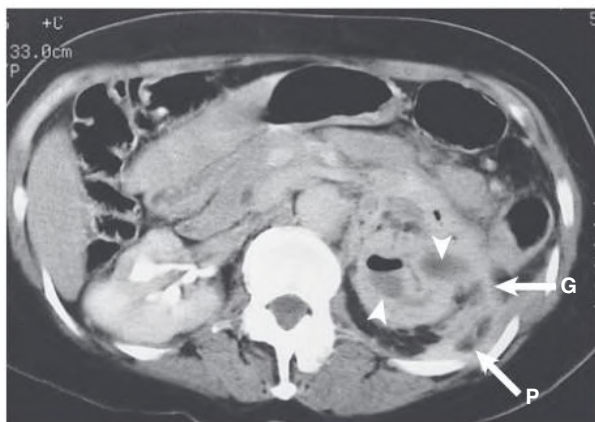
Emphysematous Pyelonephritis. Contrast-enhanced computed tomography scan shows gas (*arrowheads*) within an enlarged left kidney and marked enhancement of the Gerota fascia (*G*) and posterior perirenal space (*P*), indicative of inflammatory involvement.
